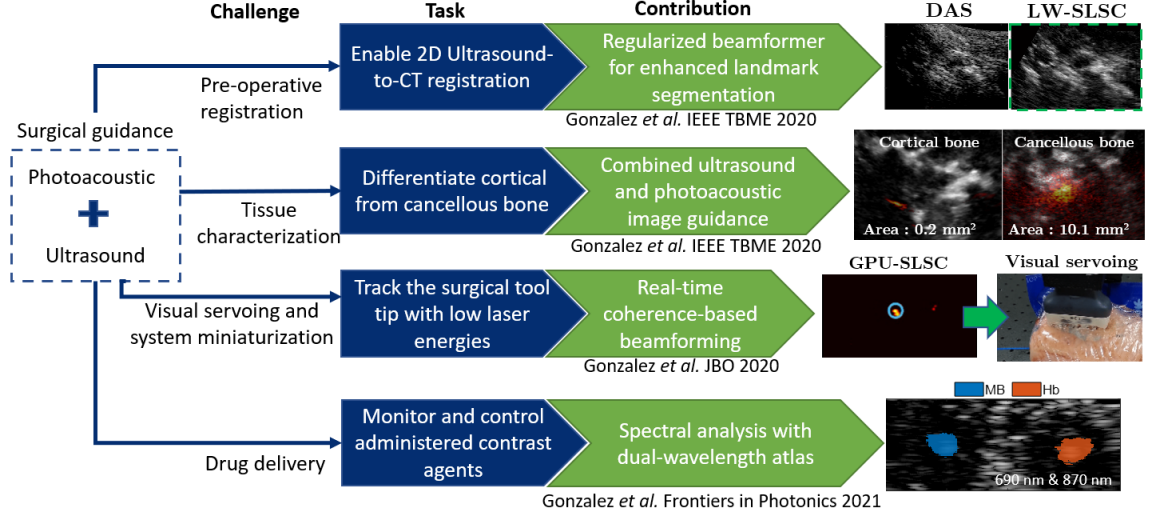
Challenges of photoacoustic and ultrasound imaging for surgical guidance, tasks, and major contributions of this thesis.
